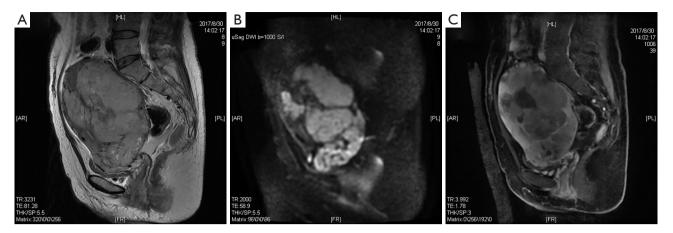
MRI at 3 months after HIFU treatment. (A) T2WI of lesions at 3 months after HIFU treatment. T2WI showed an oval-shaped clear boundary of the lesion with an uneven intermediate-to-hyperintensity signal in the posterior wall of the uterus. (B) DWI of lesions at 3 months after HIFU treatment. DWI displayed an uneven hyperintensity signal in the lesion area. (C) Enhanced imaging of lesions at 3 months after HIFU treatment. Enhanced imaging on T1WI with fat saturation showed uneven significant enhancement in the lesion with an internal non-perfusion zone. MRI, magnetic resonance imaging; HIFU, high-intensity focused ultrasound; T2WI, T2-weighted images; DWI, diffusion-weighted image; T1WI, T1-weighted images.
